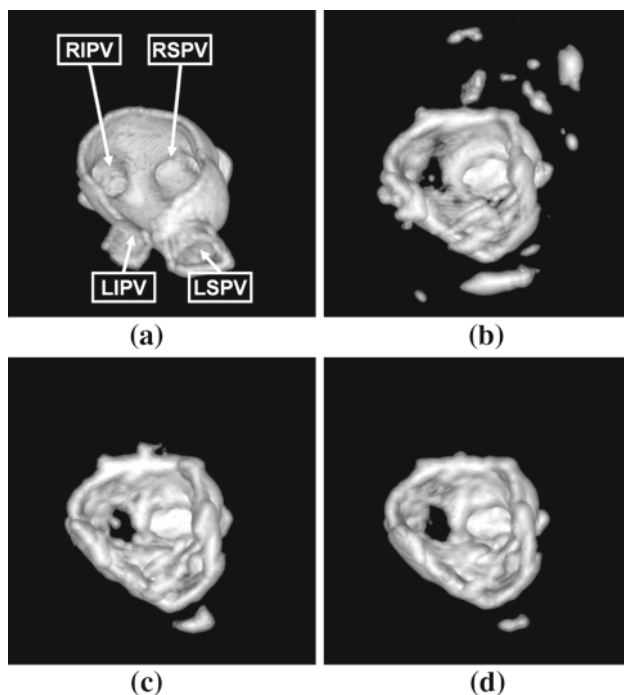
Right pulmonary vein imaging. We reconstruct 3D-ICE volumes using ICE images acquired from the catheter configuration shown in Fig. 8b. The volume in a is the gold-standard voxel map with the left inferior, left superior, right inferior, and right superior PVs shown (LIPV, LSPV, RIPV, RSPV, respectively). The volume in b is reconstructed using WAC compounding alone. The volume in c is reconstructed using WAC with RGC and RLW, and the volume in d is reconstructed using OLC with RGC and RLW. Because of ultrasound dropout, we cannot see the left PVs in our 3D-ICE volumes (b, c, and d)
